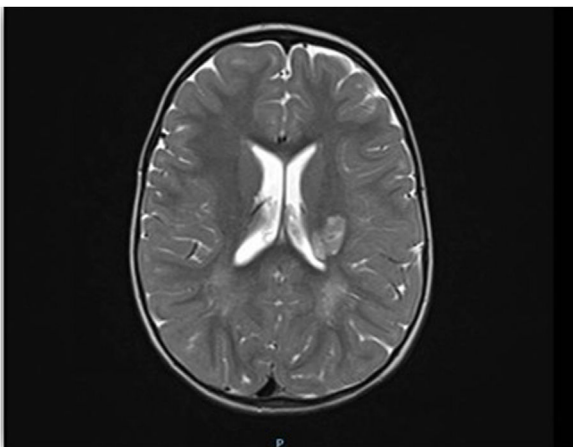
Axial T2-weighted brain MRI sequence showing an area of increased signal intensity compatible with ischaemic arterial stroke in the body/tail of the caudate nucleus, posterior limb of the internal capsule, and posterior portion of the left lenticular nucleus.
